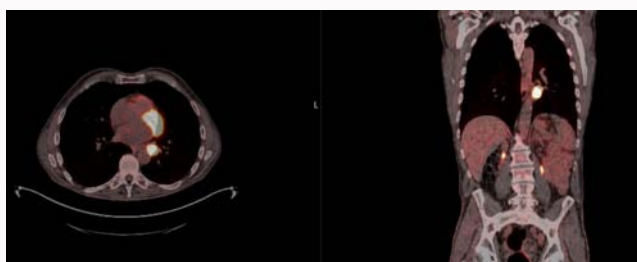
PET-CT showing 3 cm left paraesophageal solid mass with high FDG uptake.
